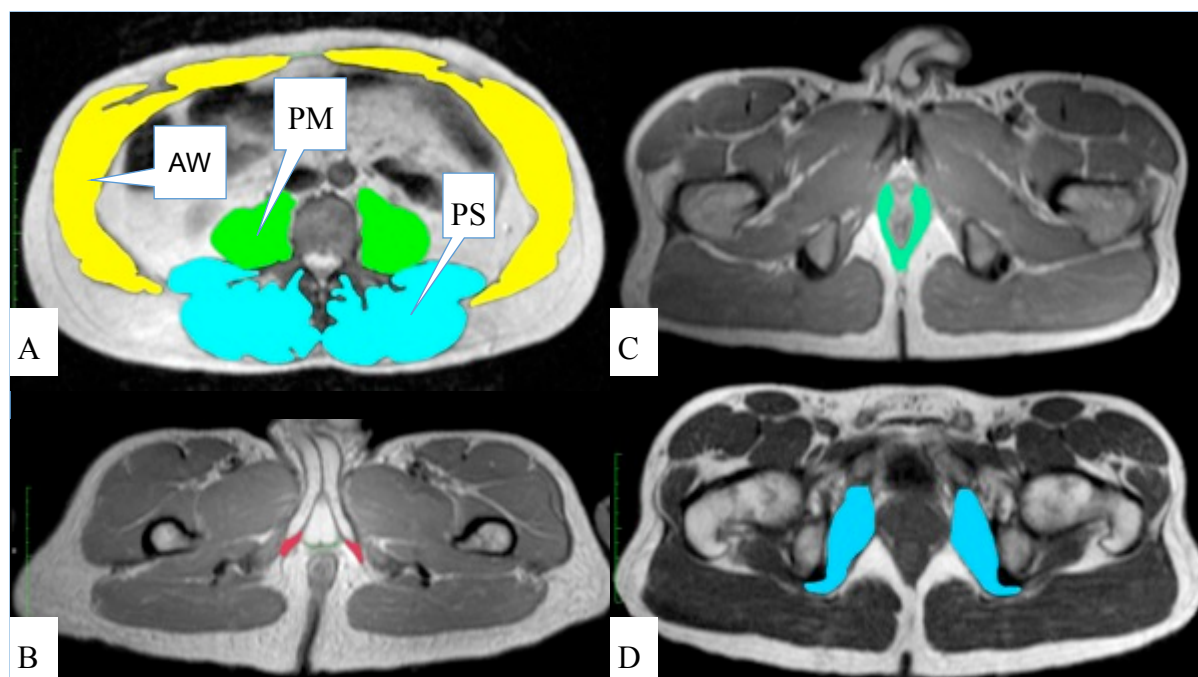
T1-weighted (A-C) and T2 weighted (D) Magnetic Resonance Images of areas measured. A) Muscle areas at 3rd lumbar vertebrae, psoas major (PM), paraspinal muscles (PS), abdominal wall (AW). B) The ischiocavernosus muscles. C) The pelvic diaphragm. D) The obturator internus muscles. Reprint from study 1.
